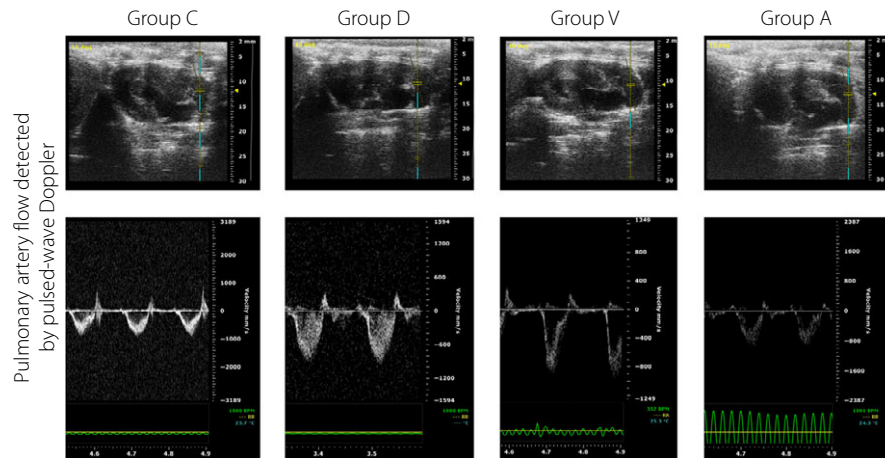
Pulmonary artery flow detected by pulse-wave Doppler.
